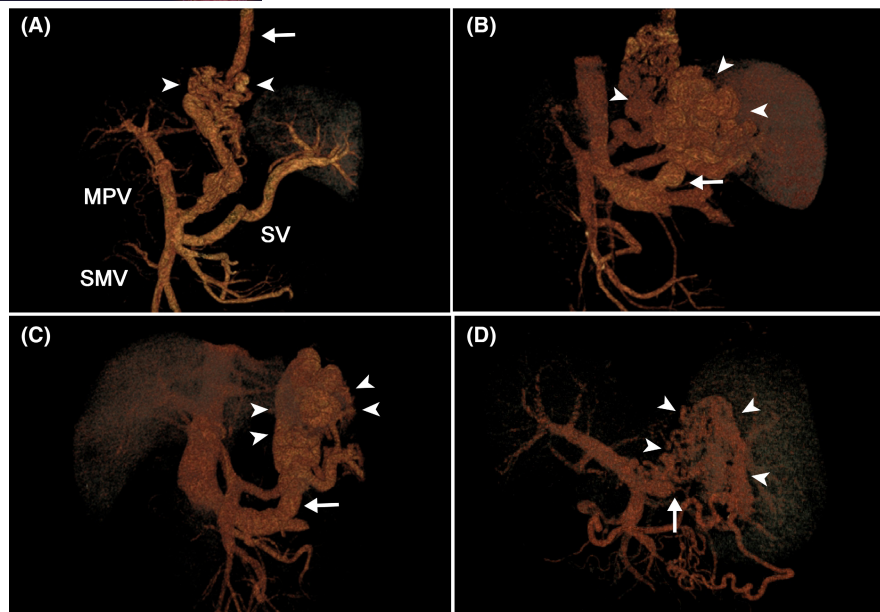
Construction of computed tomography scan in patients with four types of gastric varices (GV) according to Sarin classification. (A) Gastro-oesophageal varices type 1 (arrowhead) runs along the lesser curvature and drains into the oesophageal varices (arrow). (B) Gastro-oesophageal varices type 2 (arrowhead) draining through both oesophageal varices and a gastroduodenal shunt (arrow). (C) Large isolated gastric varices type 1 (arrowhead) draining through a gastroduodenal shunt (arrow) into the left renal vein. (D) 3D reconstruction image shows isolated gastric varices type 2 (arrowhead) caused by splenic vein occlusion (arrows). The GV developed at the collateral pathway between the short gastric vein and the left gastric vein
